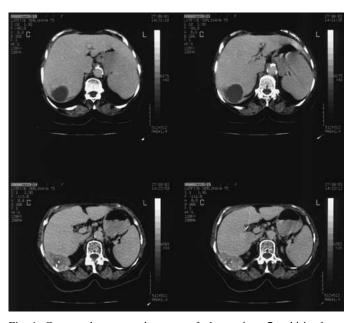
Computed tomography scan of the patient 7, which shows intraabdominal abscess due to retained gallstones.
